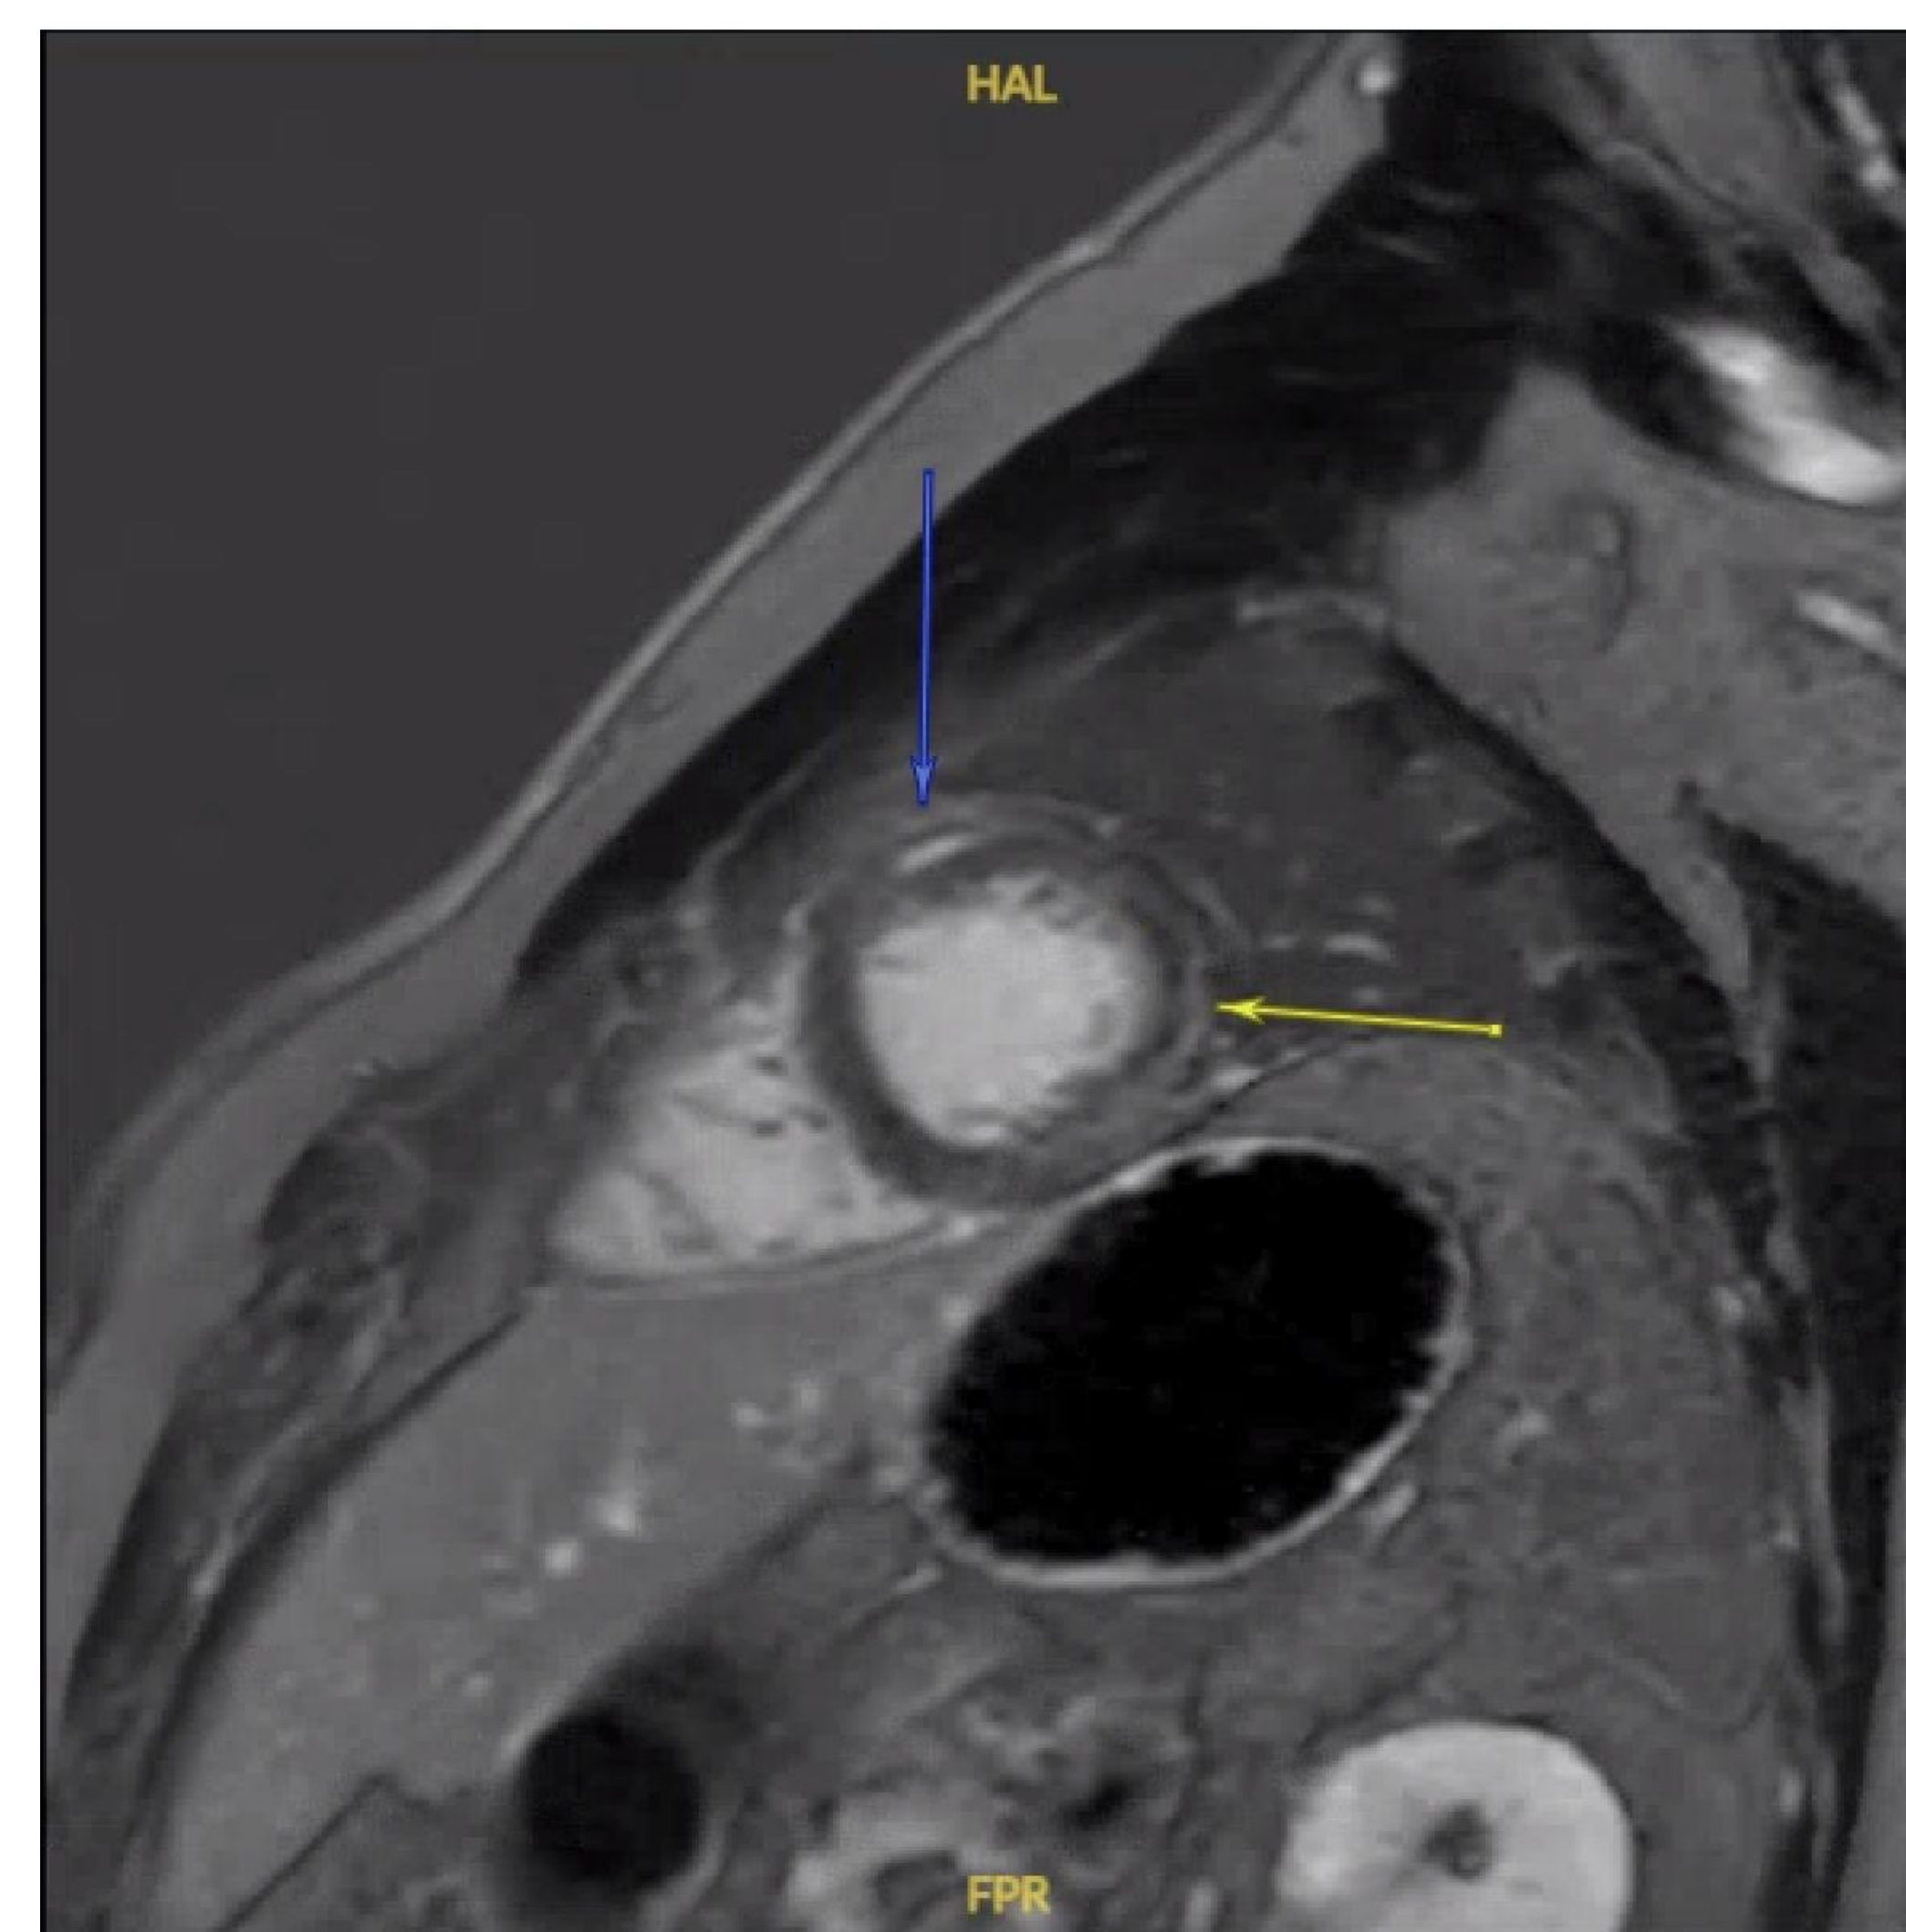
Cardiac MRI showing hyperenhancement of the anterior and lateral mid ventricular wall, suggestive of myocardial edema
